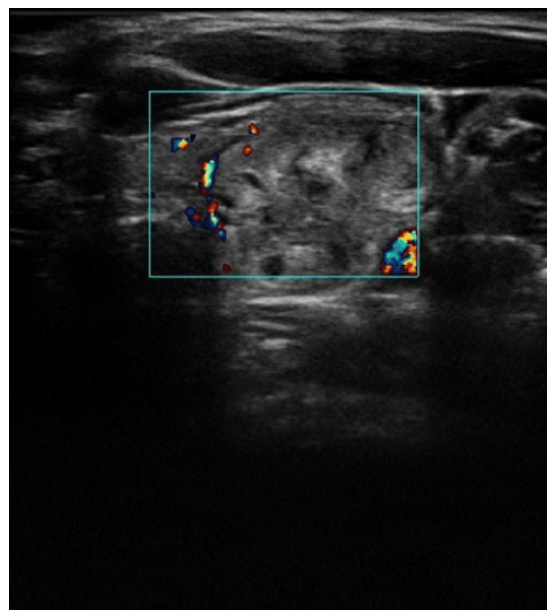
Duplex ultrasound image of thyroid. In this case the nodule presents minimal blood flow.
